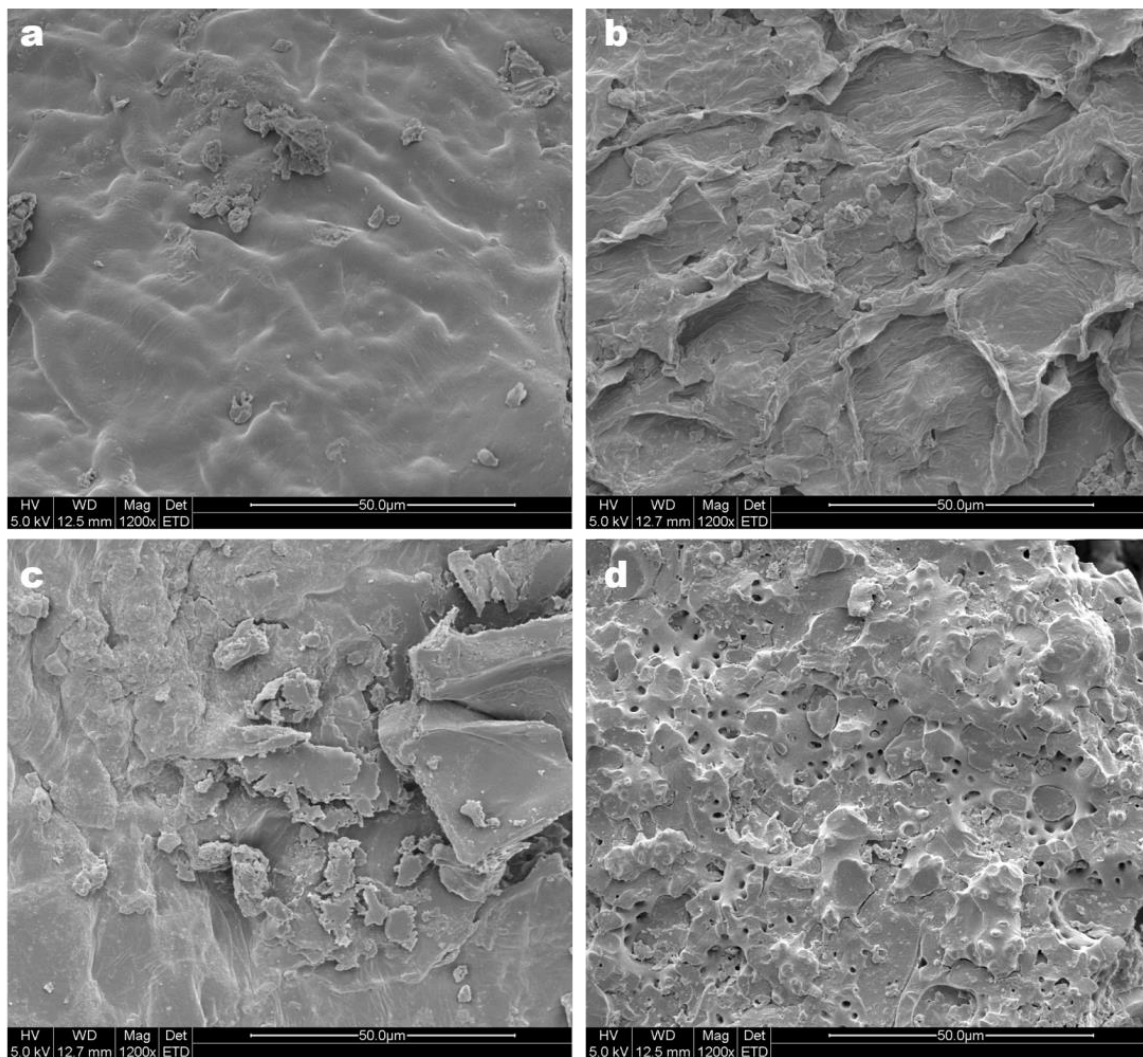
SEM observation of (a) the control treatment (CrBL-EO_{C2}); (b) pre-enzymolysis treatment (CrBL-EO_{E2}); (c) ultrasound–microwave treatment (CrBL-EO_{US2c}); and (d) pre-enzymolysis and ultrasound–microwave treatment (CrBL-EO_{EUS2}).
